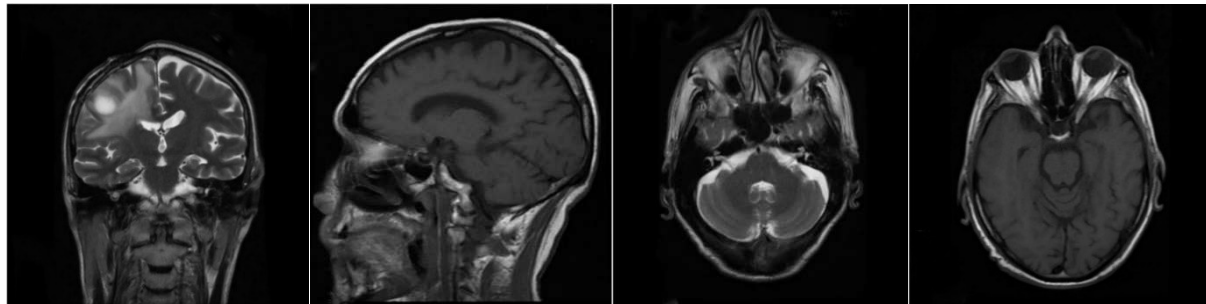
An example of MRI images acquired from different anatomical views
